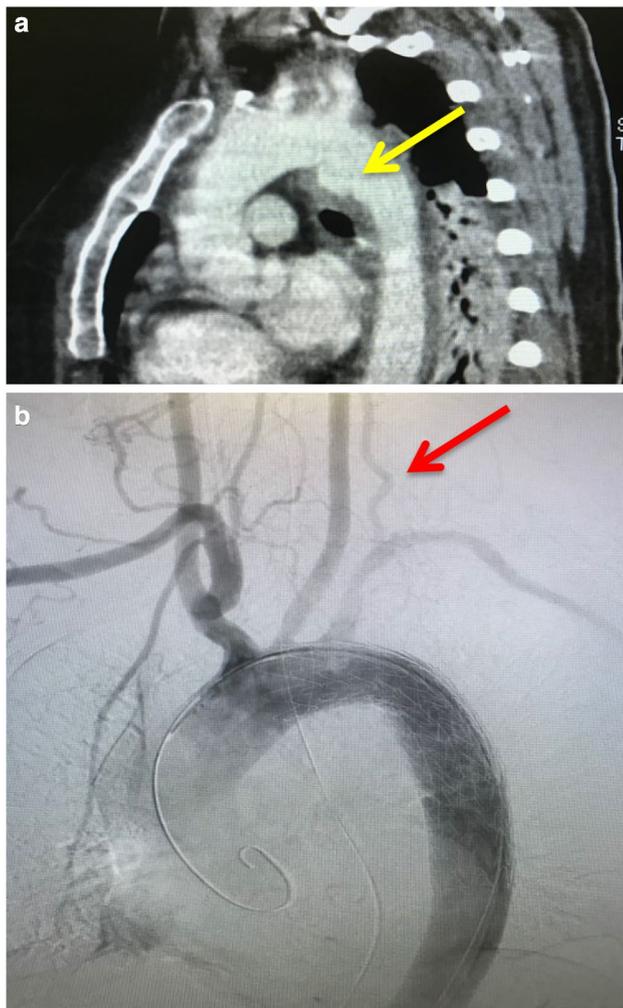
a The sagittal CECT scan of distal arch BTAI with pseudoaneurysm (yellow arrow). b We performed zone 2 TEVAR with left subclavian artery bypass because we detected retrograde left vertebral arterial flow intra-operatively (red arrow). After the surgery, however, the patient complained of slight left-hand claudication. The left arm blood pressure was approximately 40 mmHg lower than that of the right arm. *CECT* contrast enhanced computed tomography, *BTAI* blunt traumatic aortic injury, *TEVAR* thoracic endovascular aortic repair
